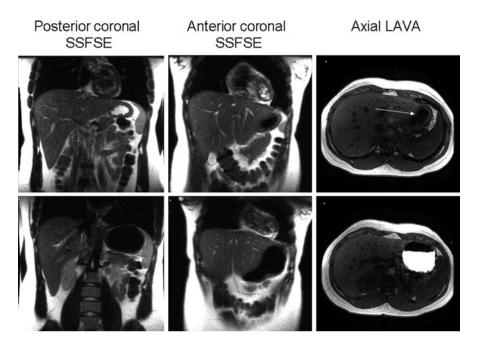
Fasting (*upper panel*) and postprandial (*lower panel*) images acquired by MRI. In the fasting half-Fourier acquisition single-shot turbo spin echo (HASTE) images, the distinction between high signal intensity fluid, which is layered posteriorly (i.e., in the dependent position) and low signal intensity air, which is anterior, is obvious. In the LAVA images, the air–fluid interface is subtle (*arrow*). Postprandially, air and fluid have low signal intensity in HASTE images but easily distinguishable on LAVA sequence (i.e., nutrient labeled with gadolinium appears bright, while air is dark). Reproduced with permission from Fidler JL, Bharucha AE, Camilleri M, Camp J, Burton D, Grimm R, Riederer SJ, Robb R, and Zinsmeister AR. Application of Magnetic Resonance Imaging to Measure Fasting and Postprandial Volumes in Humans. Neurogastroenterol Motil 2009;21(1):42–51
